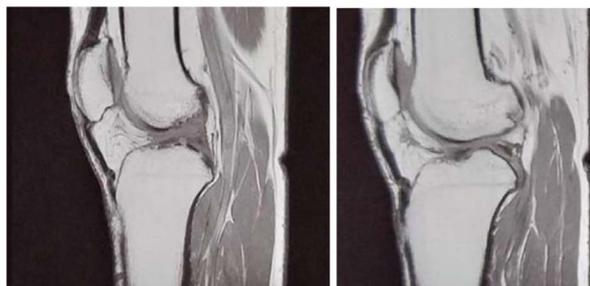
Pre-op MRI suggestive of ACL tear with meniscus tear.
